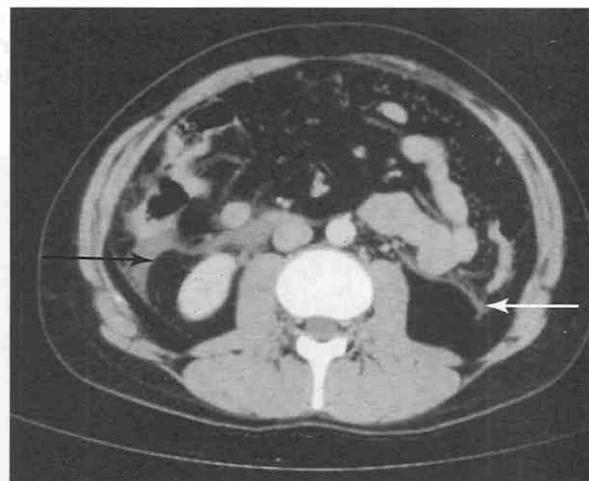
CT scan showing extensive fluid collections extending caudally into retroperitoneal fascia (arrows). The right side is more severe than the left side. Distention of fascia around normal peripheral fat has been called a "halo sign" by Susman and associates.²⁴⁶
